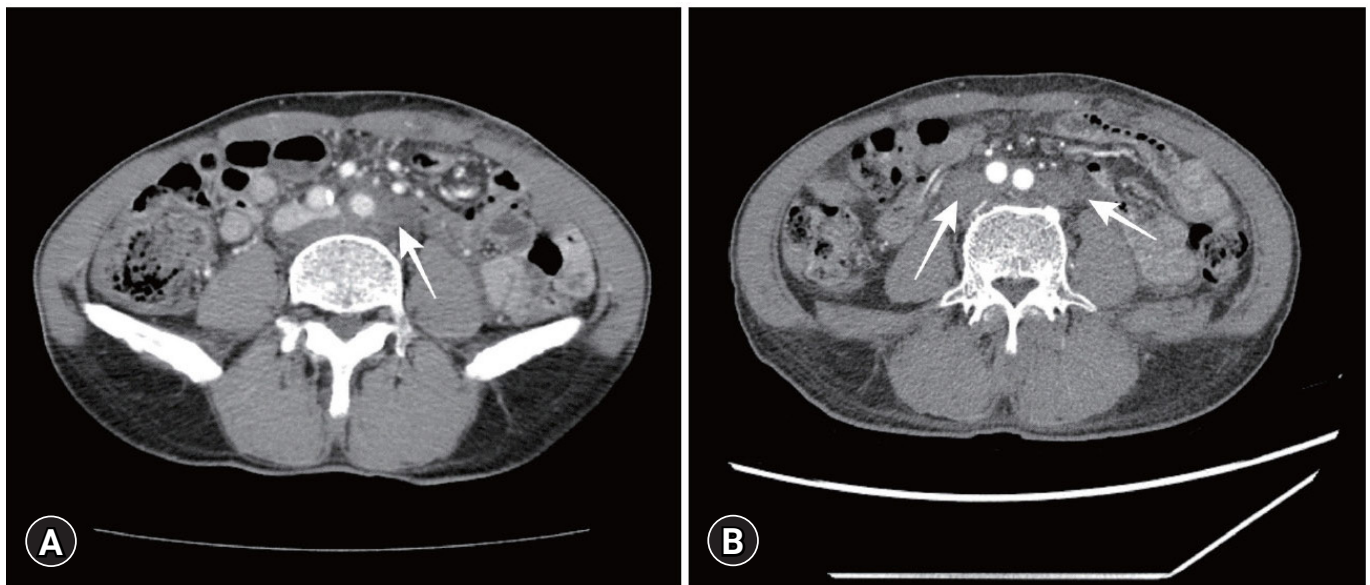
(A) Hematoma (white arrow) is seen on the initial computed tomographic scan. (B) The Hounsfield unit values of the hematoma lesions, ranging from 27 to 35, suspected mesenteric injury (white arrows) with a small amount of hemoperitoneum in the descending part of the aorta and lateral aspect of the left common iliac artery. Written informed consent for the publication of the images was obtained from the patient.
